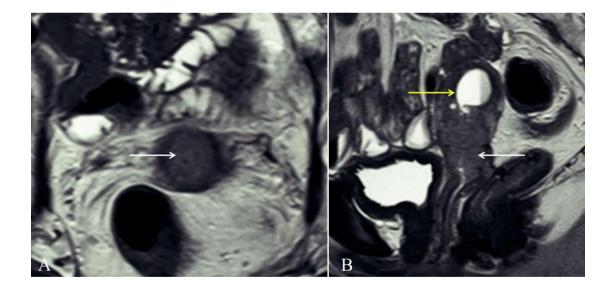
(A) Axial and (B) Sagittal T2 weighted MRI showing mass (white arrow) extending to lower uterine segment but no obvious breach in cervical stromal ring. Mass is causing cervical stenosis leading to endometrial collection (yellow arrow), staged as IIA.
